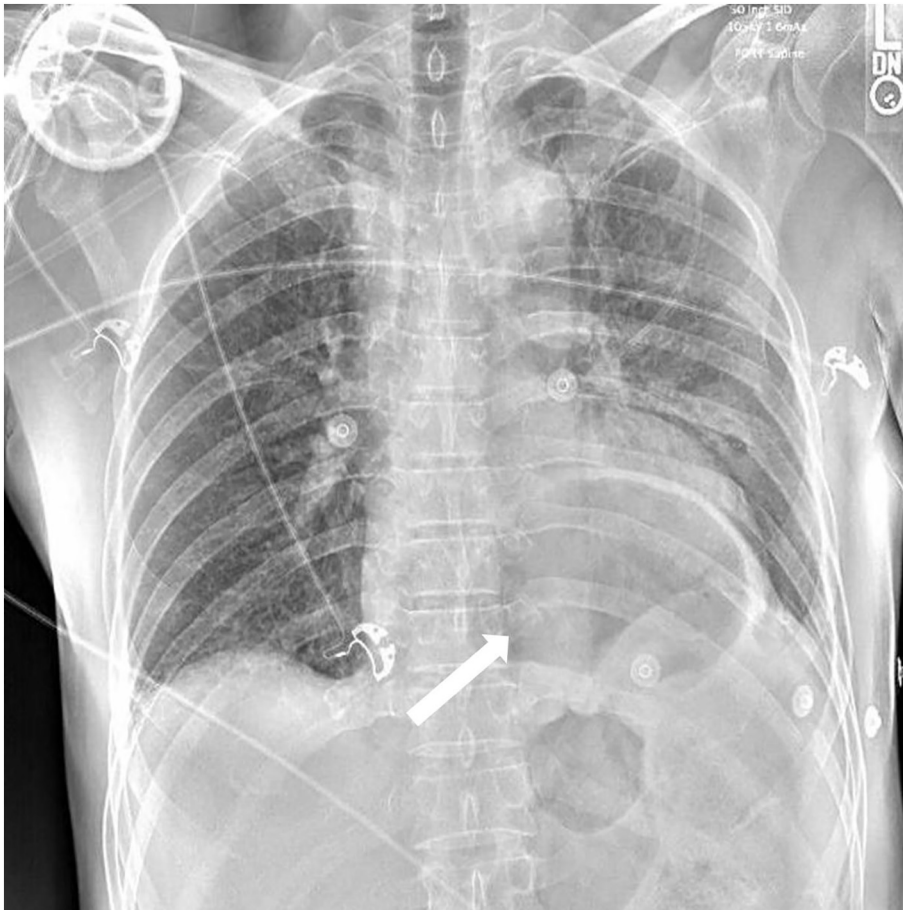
Initial chest x-ray obtained in the trauma bay. The white arrow shows a large gastric bubble projecting over the heart, raising the suspicion for a diaphragmatic injury in the setting of blunt trauma.
